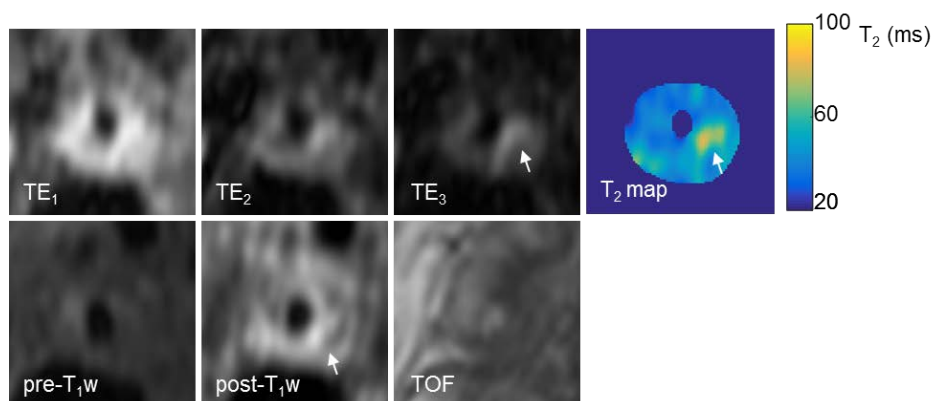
Multi-contrast MRI shows fibrotic tissue in the plaque. The fibrous tissue has higher T_2 values than the surrounding plaque components.
